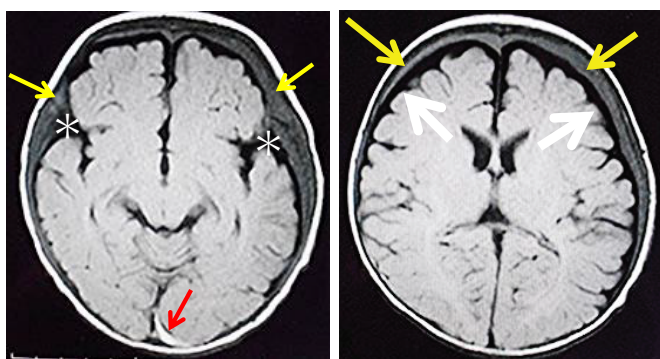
MRI 9 days after CT
